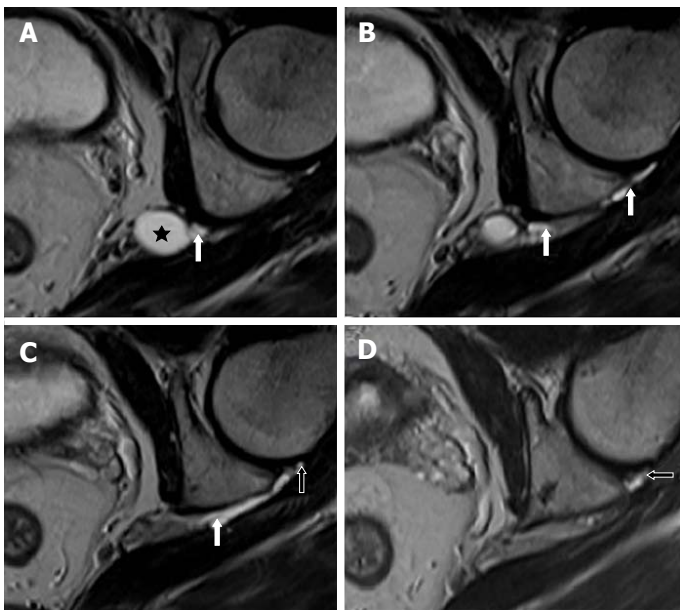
Image A-D show serial, T2-weighted, fast spin echo axial sections of the left hip joint highlighting a cyst (star) at the level of the left sciatic notch. An extension along the expected course of the articular branch of the sciatic nerve (white arrows) communicating with the posteromedial aspect of the ipsilateral hip joint (open arrows) is also seen.
